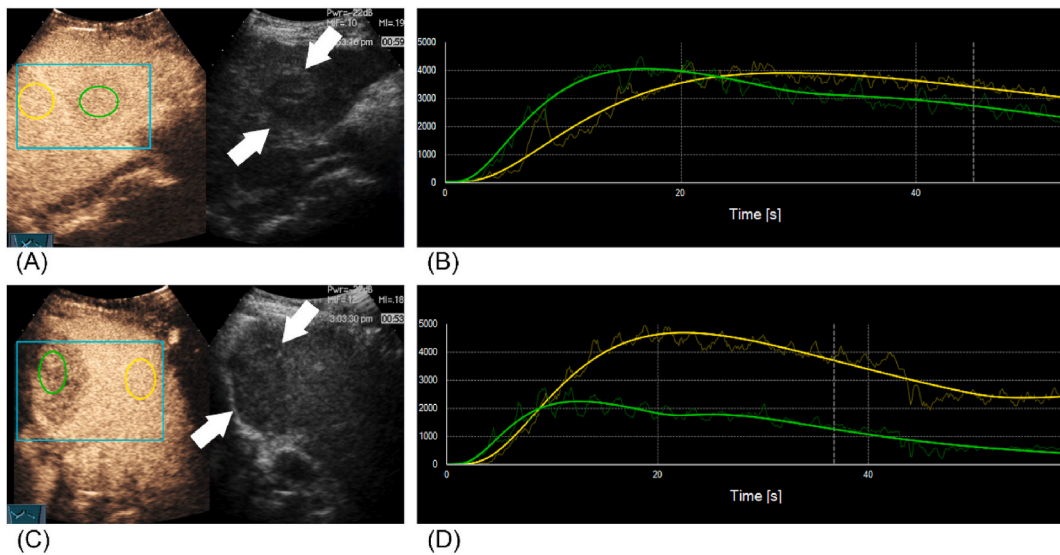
ROI selection and TIC of different lesions. (A, B) Images of a 68-year-old man displaying a nodule classified as LR-M and confirmed as hepatocellular carcinoma through surgery. (A) A 4.2×3.2 cm hypo-echoic nodule (arrowheads) in segment 6 of the right liver lobe is evident on the surveillance ultrasound (US) image, demonstrating early wash-out (<60 s; timer, 00:59) but presenting mild washout in the contrast-enhanced (CE) US images of the nodule (highlighted by the green box). (B) Representative curves of HCC derived from quantitative analysis software. (C, D) Images of a 62-year-old woman showing a nodule classified as LR-M and confirmed as liver metastases biopsy. (C) A 7.2×4.6 cm hypo-echoic nodule (arrowheads) in segment 7 of the right liver lobe is observed on the surveillance US image, indicating early wash-out (<60 s; timer, 00:48) but more marked washout in the CEUS images of the nodule (highlighted by the green box). (D) Typical curves of non-HCC lesions obtained from quantitative analysis software. (For interpretation of the references to color in this figure legend, the reader is referred to the Web version of this article.)
